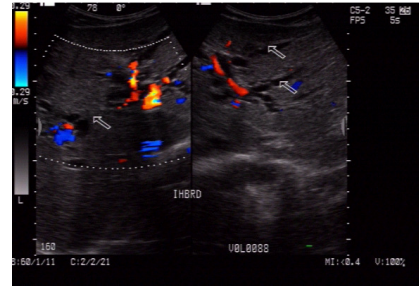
Ultrasound image of a patient showing IHBRDs (arrows)
